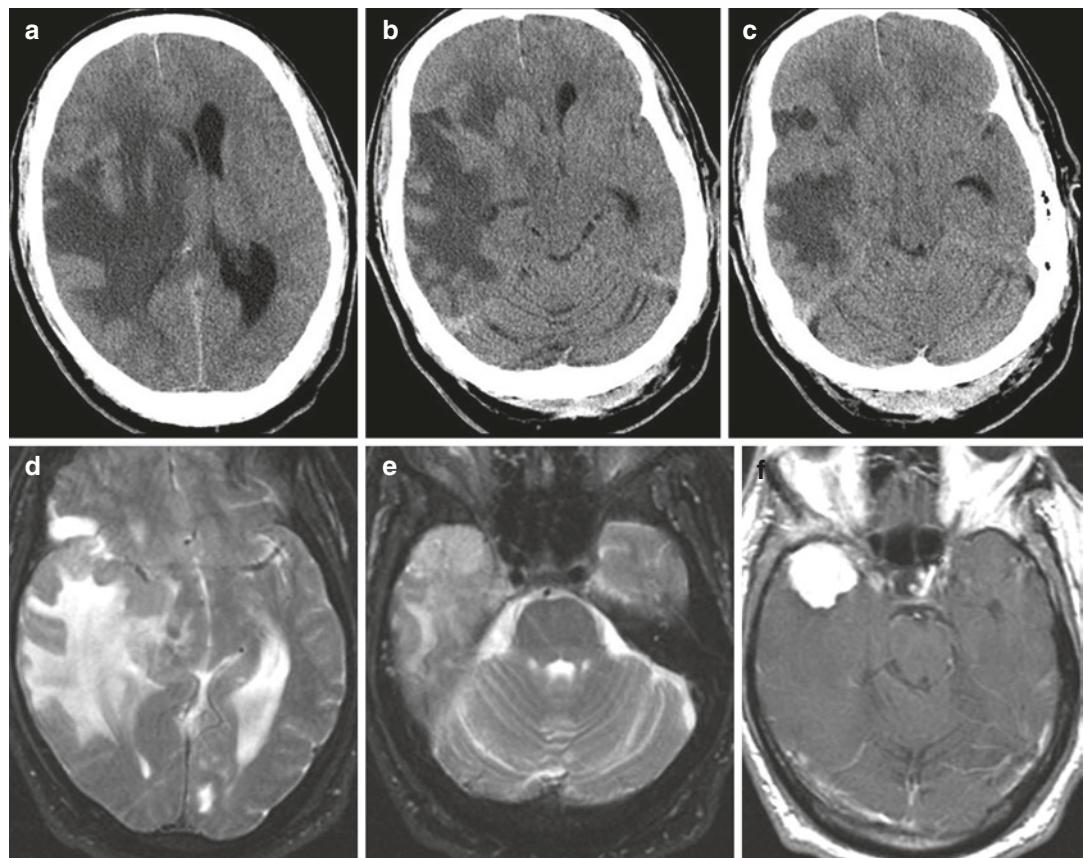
Non-contrast head CT (a–c) of a patient seen in the ED with left hemiparesis shows substantial hypodensity of the white matter in the right frontal and temporal lobes, with focal cortical hypodensity and mass effect interpreted as a large acute/early subacute infarct in the right middle cerebral artery territory. Axial
